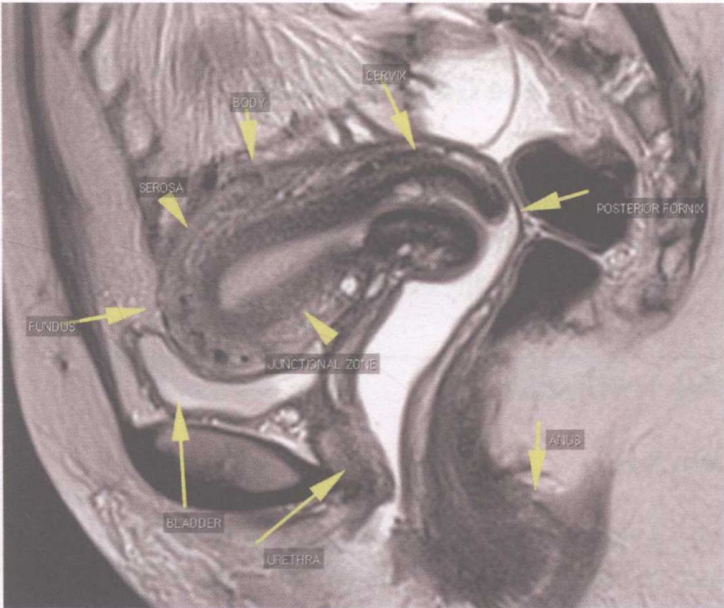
Pelvic MRI, Sagittal TSE T2 weight, demonstrating the normal zonal anatomy of the uterus
